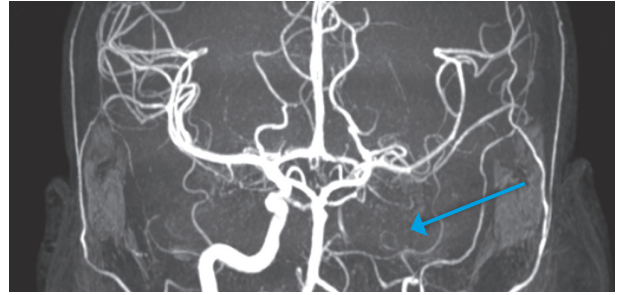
Absence of contrast in the left internal carotid artery on angio-MRI. The median cerebral artery is perfused from the anterior communicating artery.
